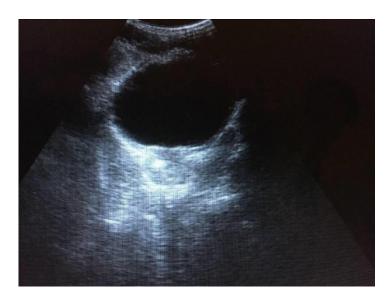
Scrotal ultrasonography of a 17-year-old Fulani refugee from Guinea Conakry with *Schistosoma mansoni* infection. Right testis immerged in anechoic scrotal fluid.
